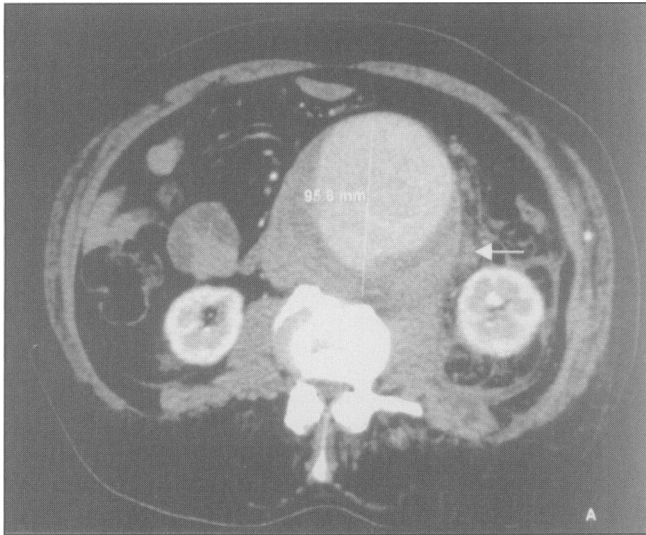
CT scan abdomen showing abdominal aortic aneurysm with contained leak posteriorly (Arrow showing site of contained leak).
